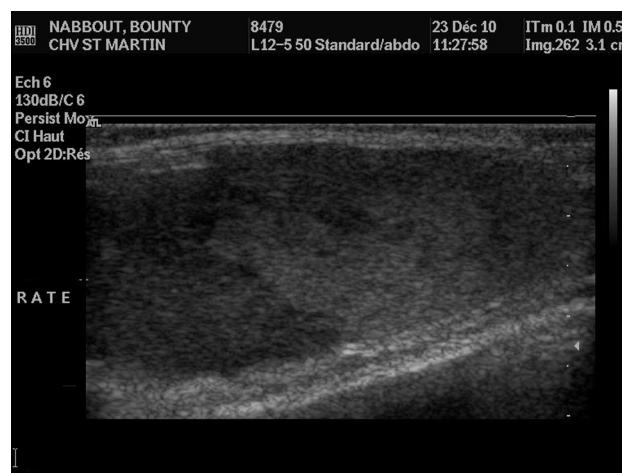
Spleen ultrasonography showing a mixed echoic parenchyma compatible with inflammation and cellular infiltration. From CHVSM.
